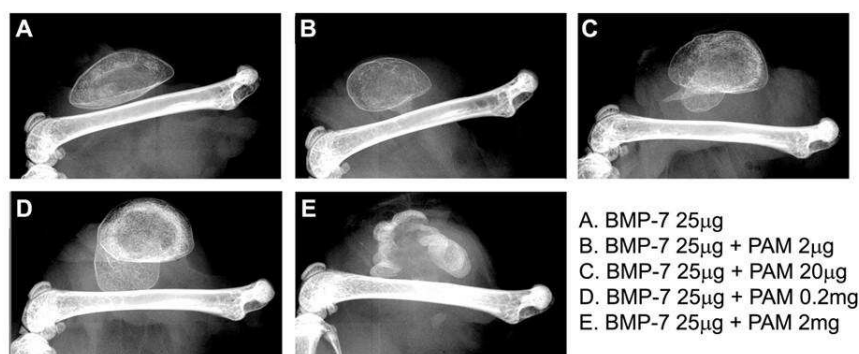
Radiographs of bone nodules
